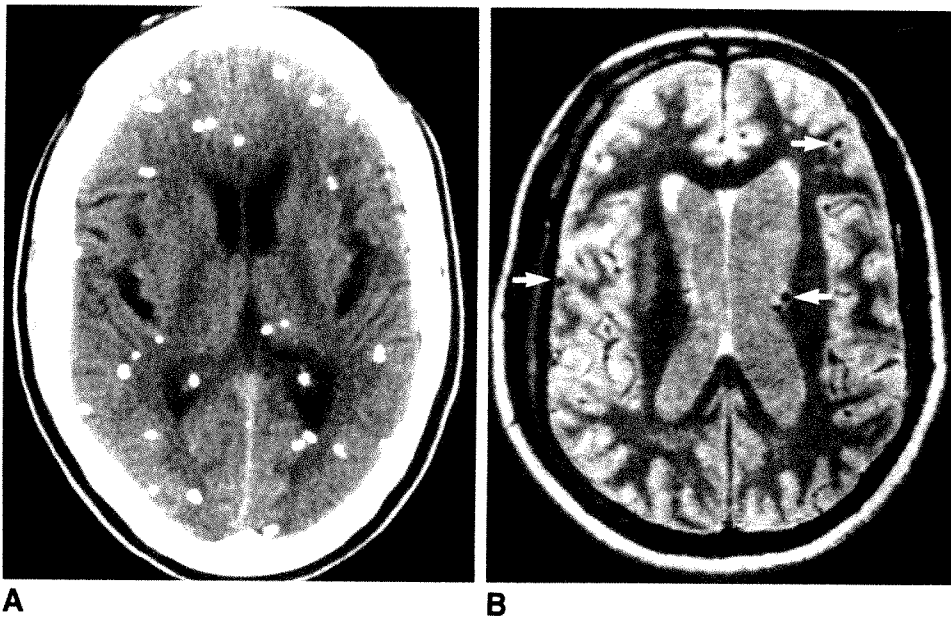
A, Nonenhanced brain CT scan reveals numerous small parenchymal calcifications caused by old cysticercosis lesions.
